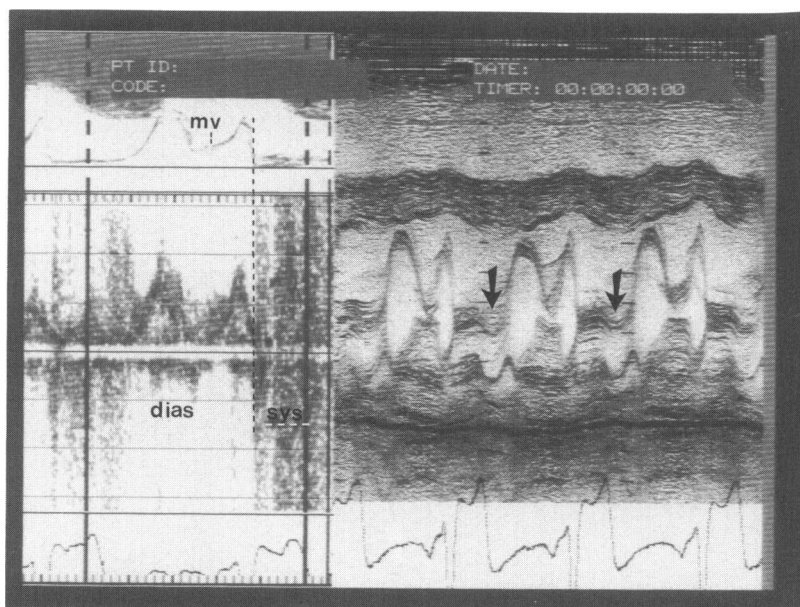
Mitral valve prolapse. On the right side, the mitral valve is seen to prolapse in late systole (arrows). However, the Doppler echocardiogram on the left side shows there is systolic turbulence immediately following closure of the mitral valve consistent with holosystolic mitral regurgitation.
